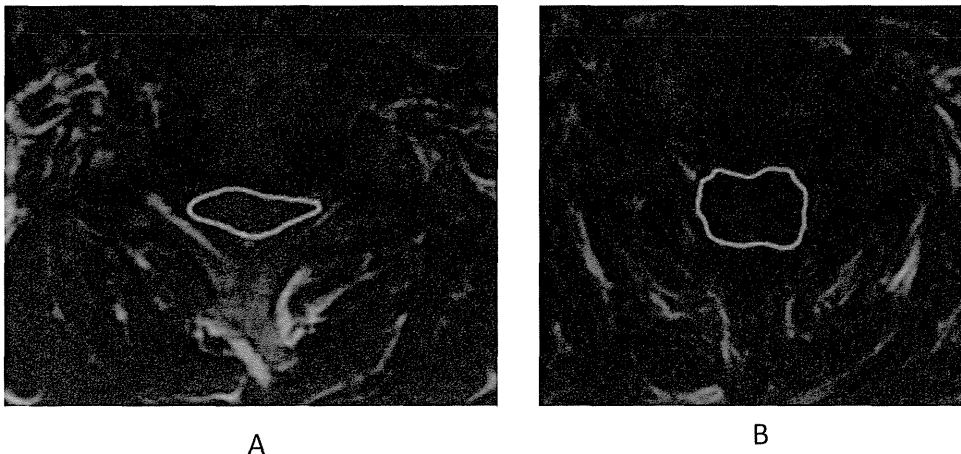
Cross-sectional area within the cervical spinal canal at the responsible level was measured on the basis of T1-weighted magnetic resonance imaging using Adobe Photoshop CS4 and Scion Image before (A) and 3 years after surgery (B).
